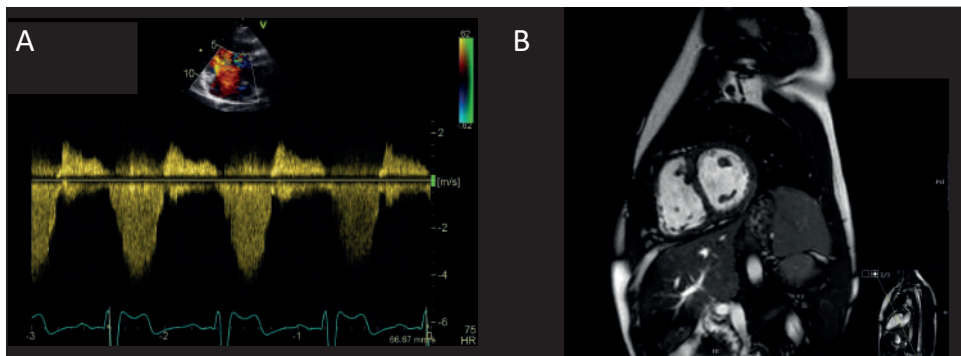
A 13 year-old patient with transposition of the great arteries for which an arterial switch operation was performed at the age of 10 days. This patient developed a stenosis in the left pulmonary artery, resulting in an increased right ventricular pressure. A: echocardiographic evaluation of the tricuspid regurgitation jet (peak tricuspid regurgitation gradient 53 mmHg). B: short axis view on CMR showing flattening of the interventricular septum (D-shaped left ventricle).
